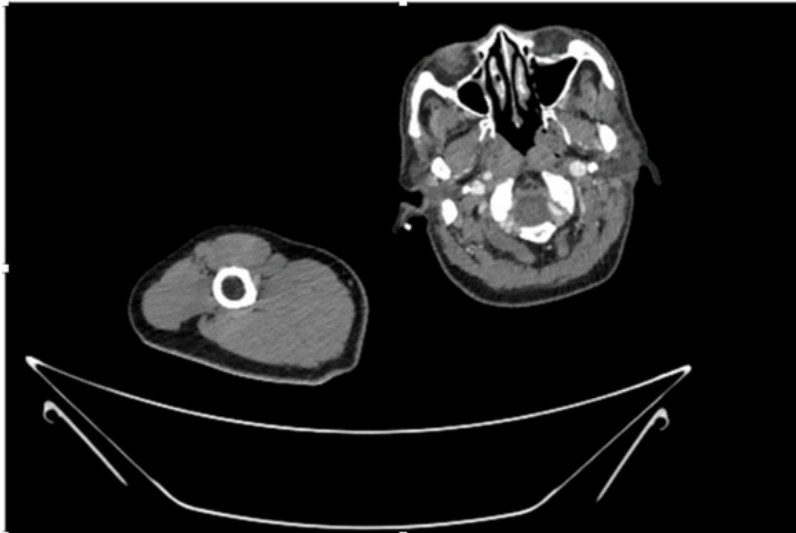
CT Angiogram at mid arm showing totally occluded right brachial artery.
